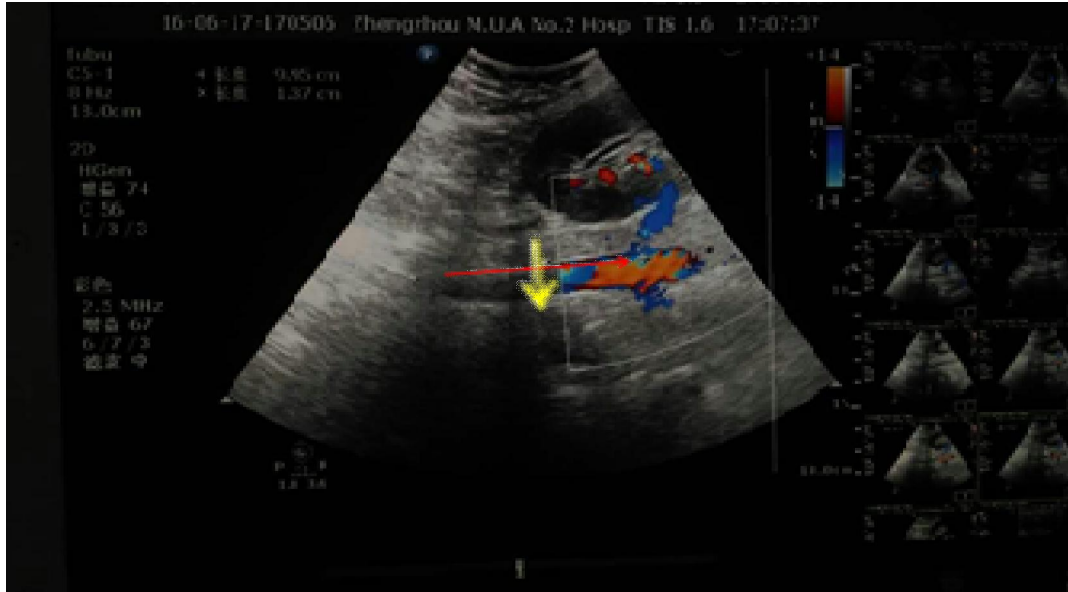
The preoperative ultrasonic detection of abdominal aorta, and measured. Red arrows to the bifurcation of the abdominal aorta and renal artery opening between the distance, yellow arrows to the abdominal aorta.
